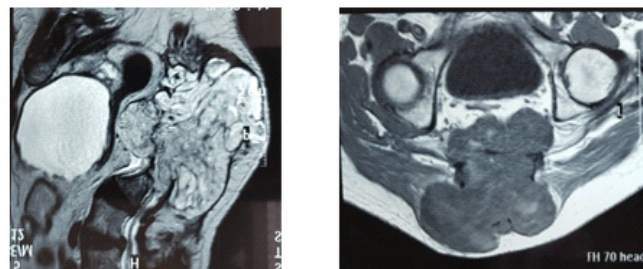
Magnetic resonance imaging (MRI) showing a large mass arising below the level of second sacral vertebra with associated destruction of both anterior and posterior sacral walls, rectal compression and subcutaneous extension
